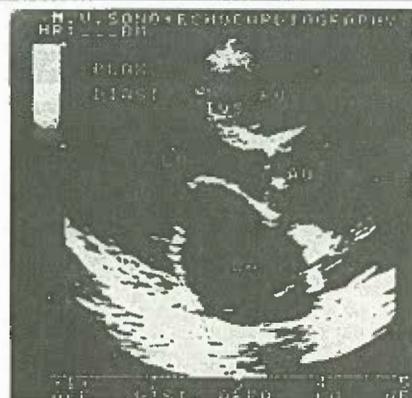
2D Echo in parasternal long axis view showing enlarged LV and LA from a patient with AR
